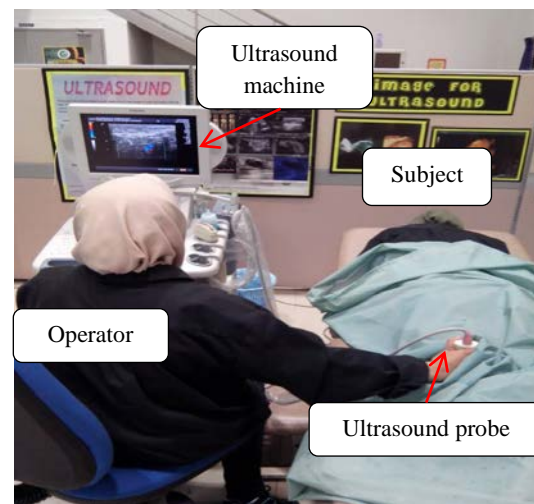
Leg scanning of the subject using ultrasound.
